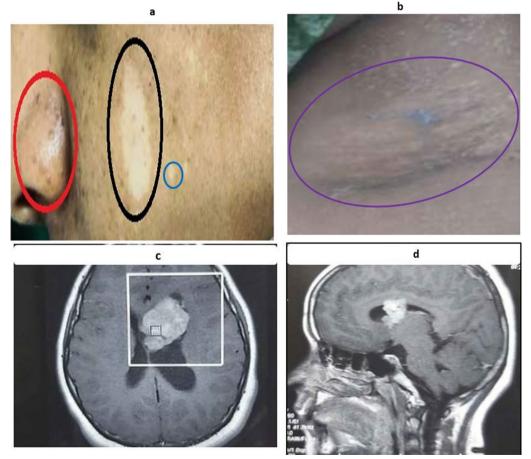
a Angiofibroma (red circle), ash leaf patch (black circle), confetti lesions (blue circle) on the face of the patient. b Shagreen patch on the back (violet circle). c MRI plain and d MRI with contrast showing location of the tumour
